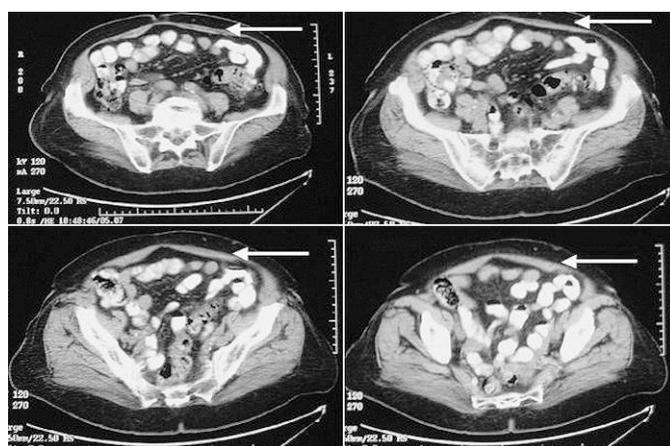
Abdominal CT after 4 months without haematoma.
